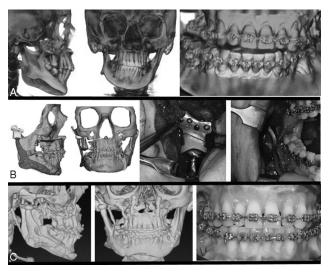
Unilateral alloplastic TMJ reconstruction and orthognathic surgery after right condylar resection. (A) Preoperative frontal and lateral views of the CBCT reconstructions, as well as reconstructed occlusal view. (B) Surgical virtual planning for TMJ reconstruction using a customized device, intraoperative views of prosthesis installation. (C) Postoperative frontal and lateral views of the CBCT reconstruction and final occlusion at a week and 6 months follow-up, respectively. TMJ, temporomandibular joint.
